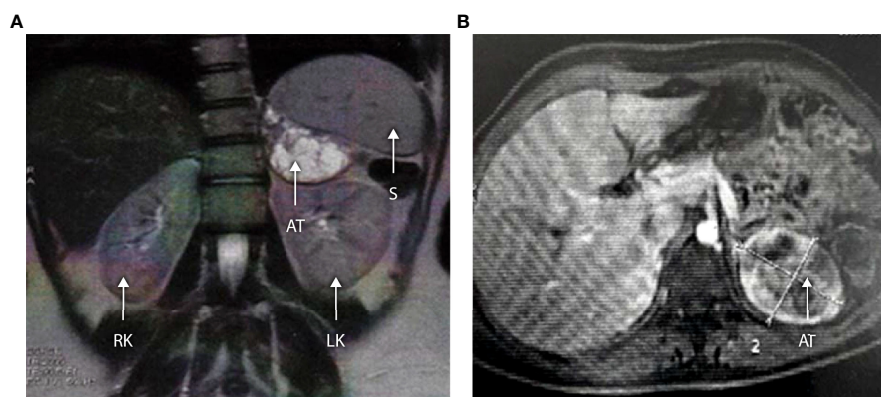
(A, B) Abdominal MRI scan in a 16-year-old with 3 β HSD2 deficiency (Patient B II-1). Axial and coronal sections demonstrate a large left-sided adrenal tumor measuring 63 × 52 × 51 mm. The lesion shows central cystic degeneration and is pushing the kidney downwards. RK, right kidney; LK, left kidney; S, spleen; AT, adrenal tumor.
